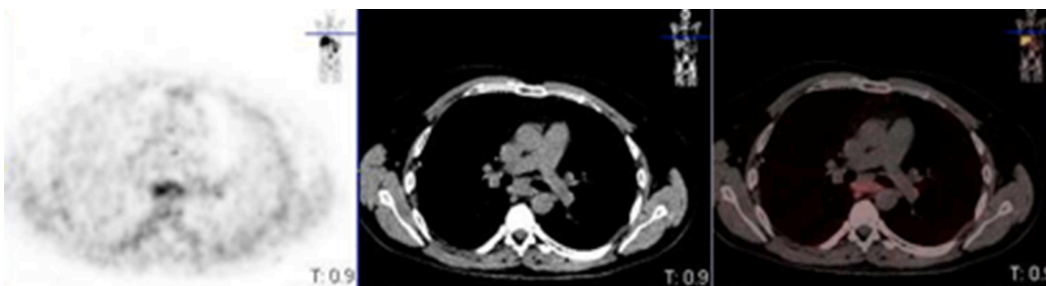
^{18}F -Choline Sub-carinal lymph nodes: These were the most intense lymph nodes noted (SUVmax 4.91)
